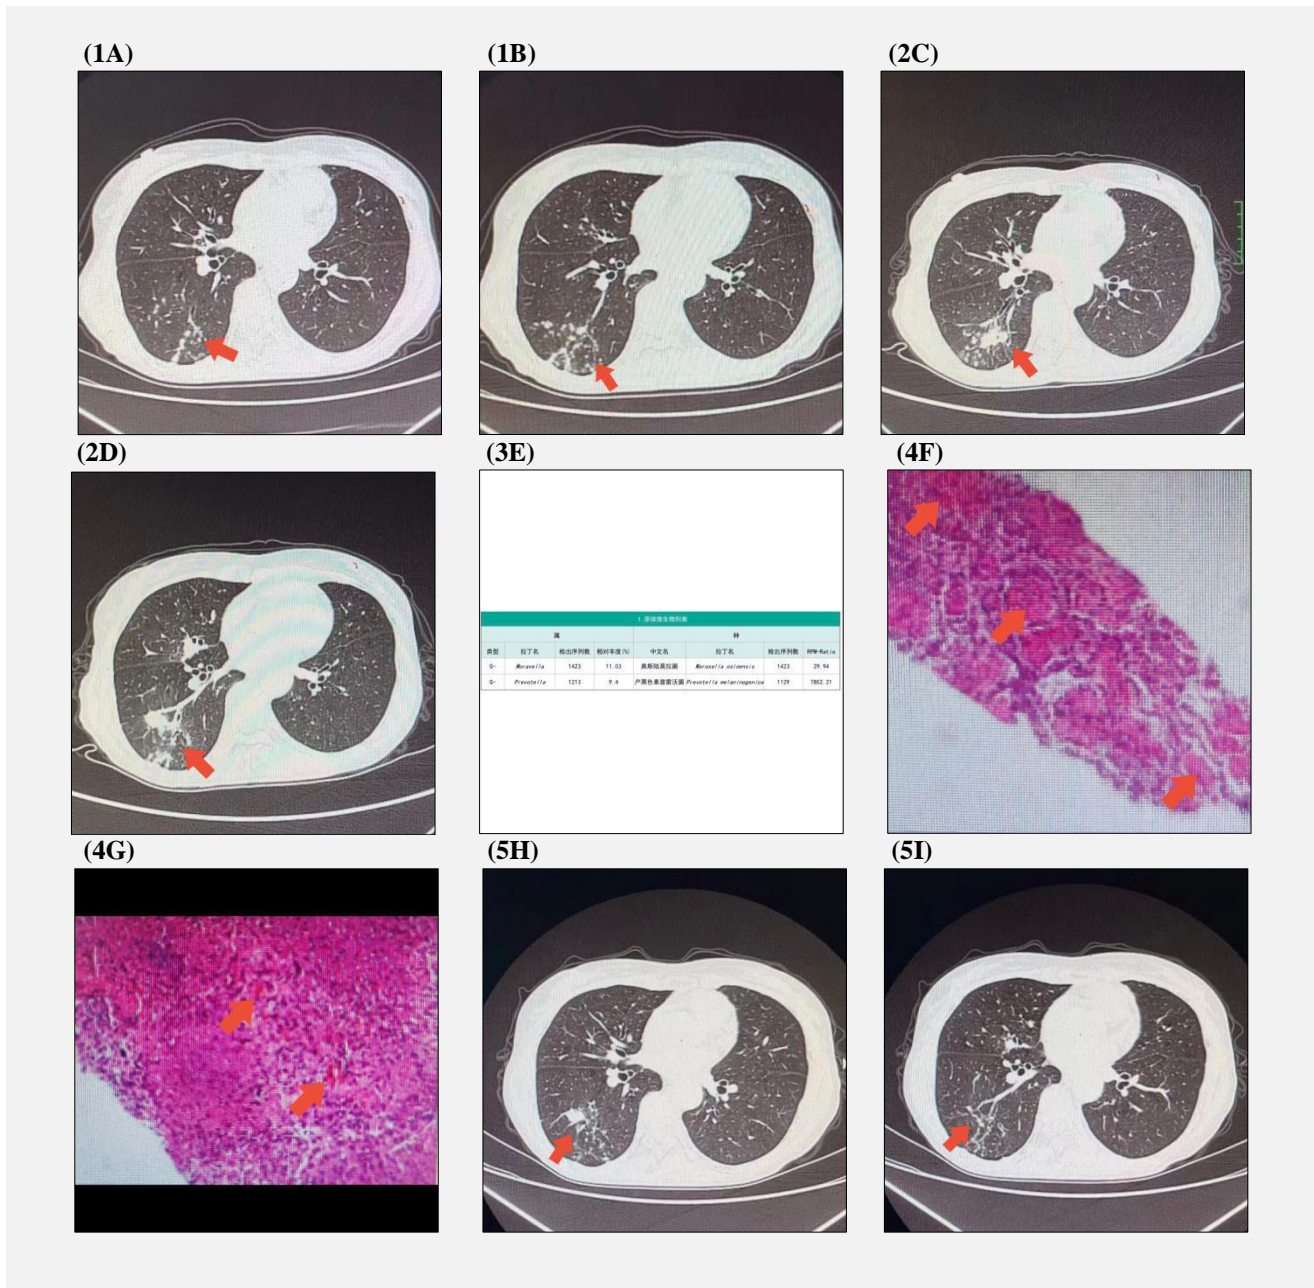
The patient's 2022-01-30 chest CT findings: nodule-like high-density shadow and striae shadow in the lower lobe of the right lung with unclear borders, considering inflammatory lesions (Figure 1A - B). Figure 2. Right lower lobe of the lung nodular-like high-density shadow increased more than before, and the striated shadow increased slightly more than before, considering inflammatory lesions progressed more than before (Figure 2C - D). Figure 3E. Alveolar lavage fluid NGS results suggesting *Moraxella oxytoca* sequence number 1,423; *Prevotella melanogaster* sequence number 1,129. Figure 4. Lung tissue sent for examination suggested that fibrous emboli and necrotic material were seen in the alveolar cavity (Figure 4F - G). Figure 5. Nodular hyperdense shadow and striae shadow in the lower lobe of the right lung were reduced compared with the previous one, considering the inflammatory lesion was absorbed compared with the previous one (Figure 5H - I).
